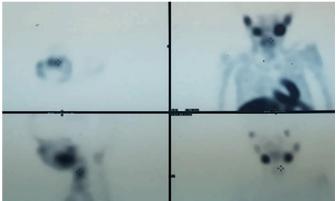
Parathyroid scintigraphy was negative for adenoma.
